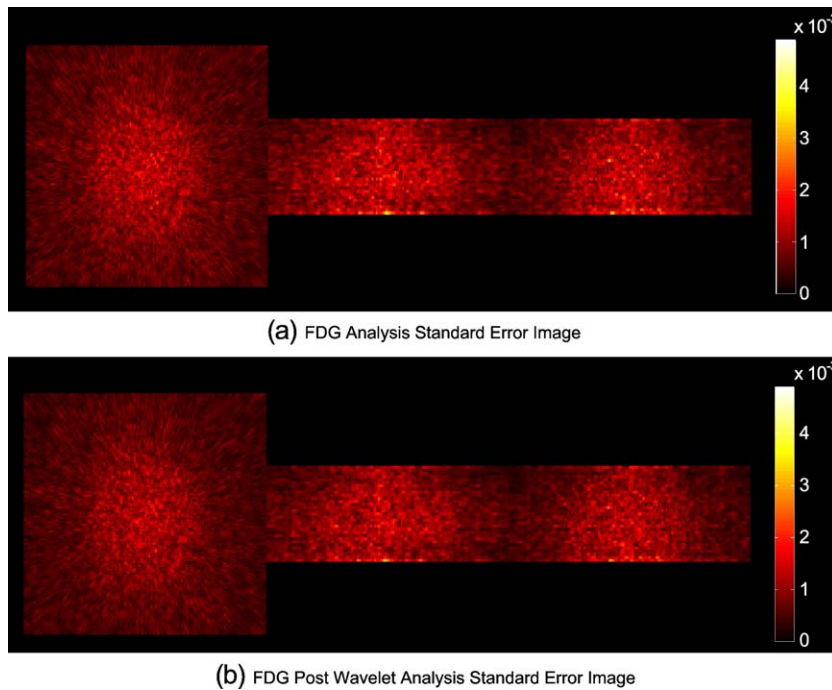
Glucose metabolism rate as measured in a PET FDG scan. The image has been linearly thresholded in the wavelet domain. This is an image of the associated errors.
